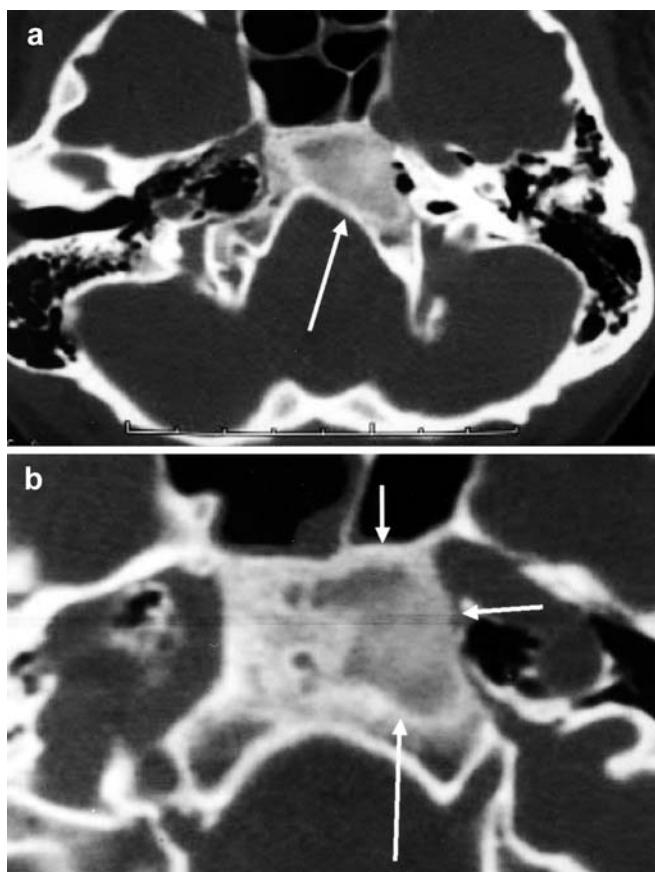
a, b. CT scan. a Ground-glass appearance of the lesion with minimal expansion (*arrow*). b Image more cranial than image a. Note the sclerotic border of the lesion (*arrows*)
